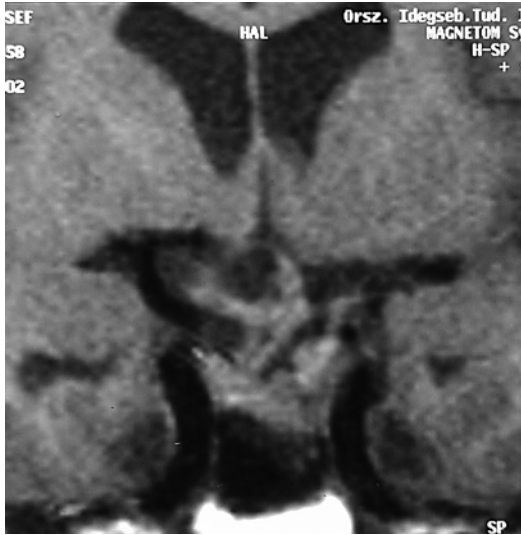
Control MR image of the tumor removed from a transcallosal approach (postoperative scan)
